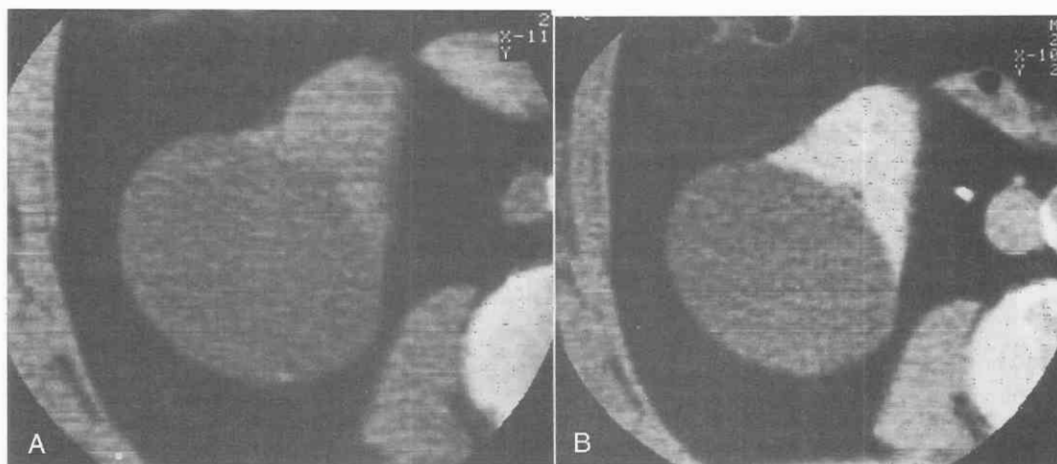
Simple renal cyst. Unenhanced (A) and contrast-enhanced (B) CT scans show that the mass is round, with a smooth margin and distinct margination from adjoining renal parenchyma. It has a homogeneous water density and does not enhance (precontrast and postcontrast attenuation value = 7 HU) and has no discernible wall thickness.
